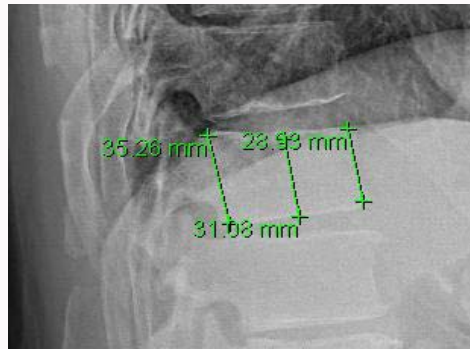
Lateral radiographs of the lumbar spine with measurement of vertebral height in the anterior, middle and posterior section.
